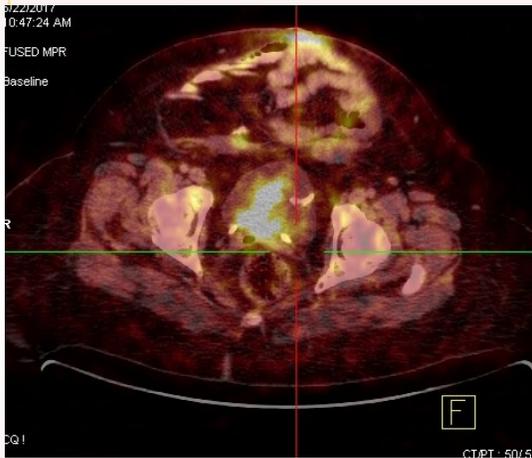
Female 43 years old, with Ovarian Cancer who had a PET/CT study to evaluate restaging post treatment (surgery & chemotherapy).
